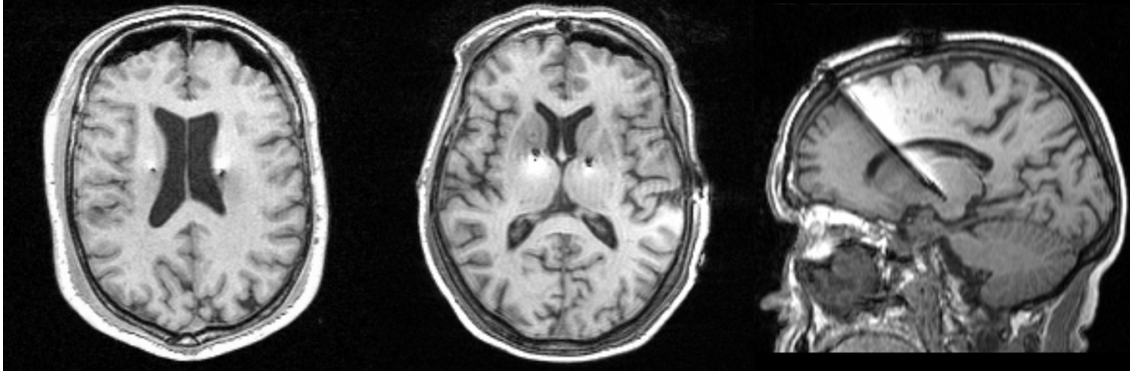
Examples of post-op MRI of subjects with bilateral pneumocephalus (left image - axial view), bilateral pneumocephalus (center image - axial view) and transventricular DBS lead implantation (right image - sagittal view).
